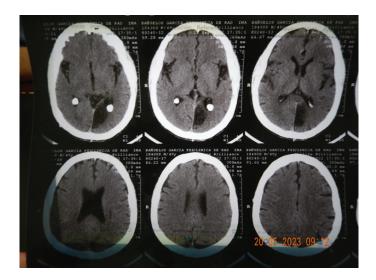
The CT scan shows a relatively large area of atrophy in the area that supplies the left posterior artery on the left.
